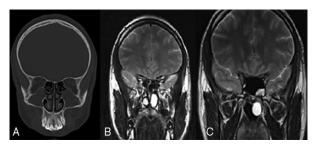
A, Coronal CT showed loss of aeration at both maxillary sinuses. B, T1-weighted MRI showed elongation of polyps to choana. C, T1-weighted MRI showed hyperintense appearance of the polypoid mass protruding though the oropharynx. CT, computed tomography; MRI, magnetic resonance imaging.
